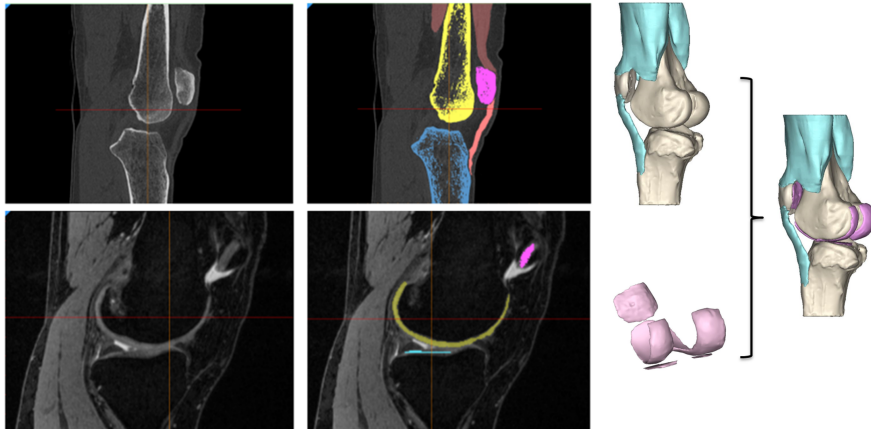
Original Vs. masked CT and MRI scans
